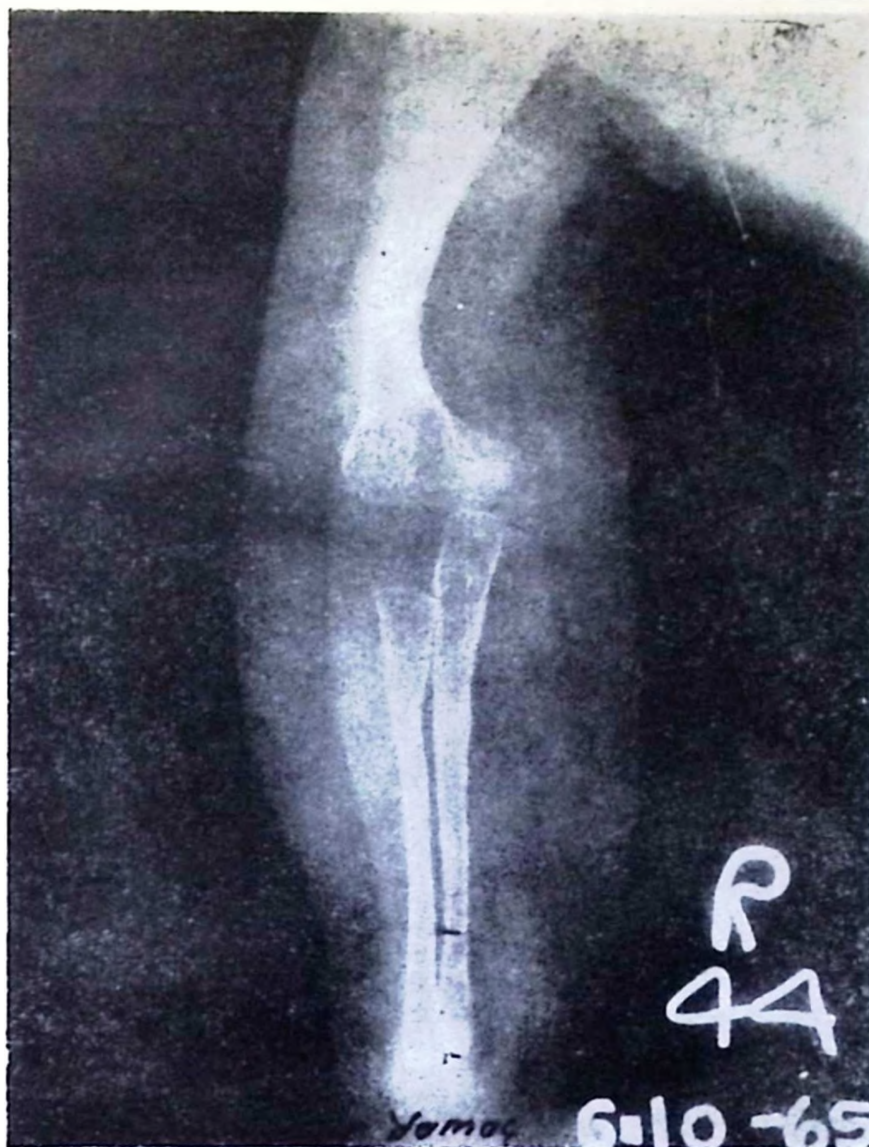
X-ray of right arm showing some thickening of the cortices, complete healing of the fractures and good medulla formation.
